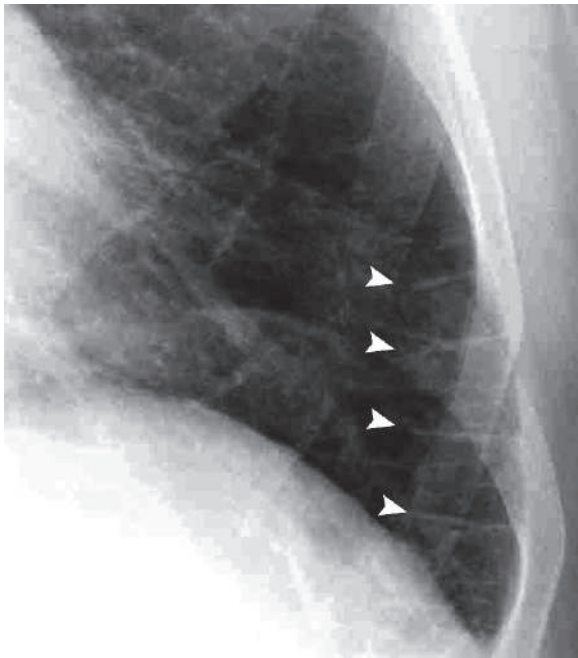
Posteroanterior plain chest radiograph shows Kerley B lines (arrowheads)
